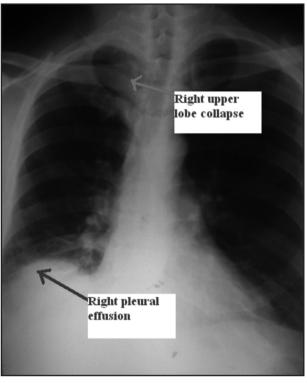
Chest radiograph of patient showing right upper lobe collapse with right pleural effusion
